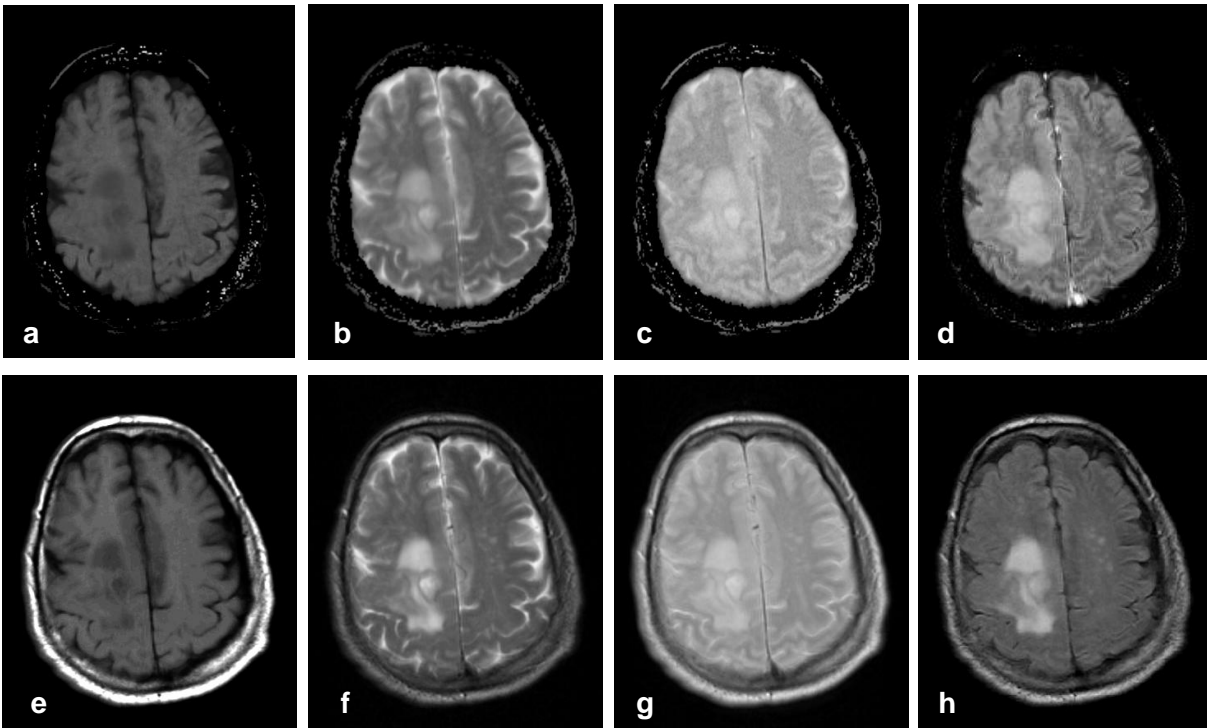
Patient (male, 69 years) with glioblastoma; Synth. images: (a) T_1 -w. with $TR/TE = 500/14$ ms, (b) T_2 -w. with $TR/TE = 4000/98$ ms, (c) spin density-w. with $TR/TE = 4000/16$ ms, and (d) FLAIR with $TR/TI/TE = 6500/2200/105$ ms; (e-h) corresponding acquired images from separate sequences.
